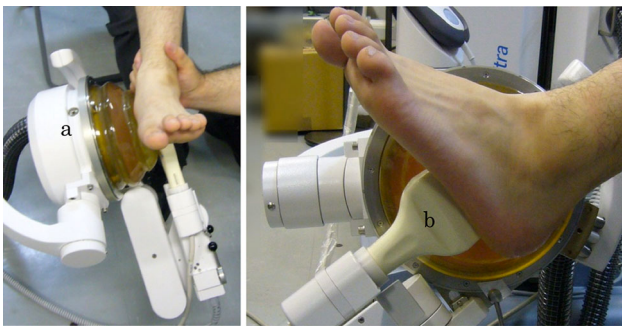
Shock wave generator and position of patients' foot during ESWT. a Shock wave generator, b ultrasonography probe
